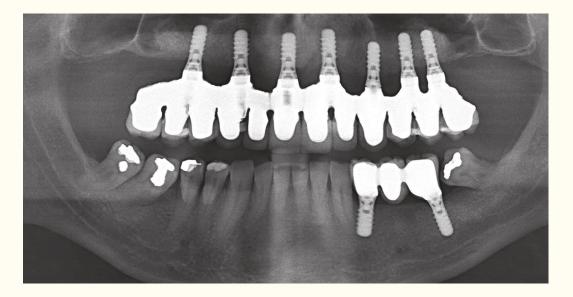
Panoramic radiograph after one-year follow-up.
